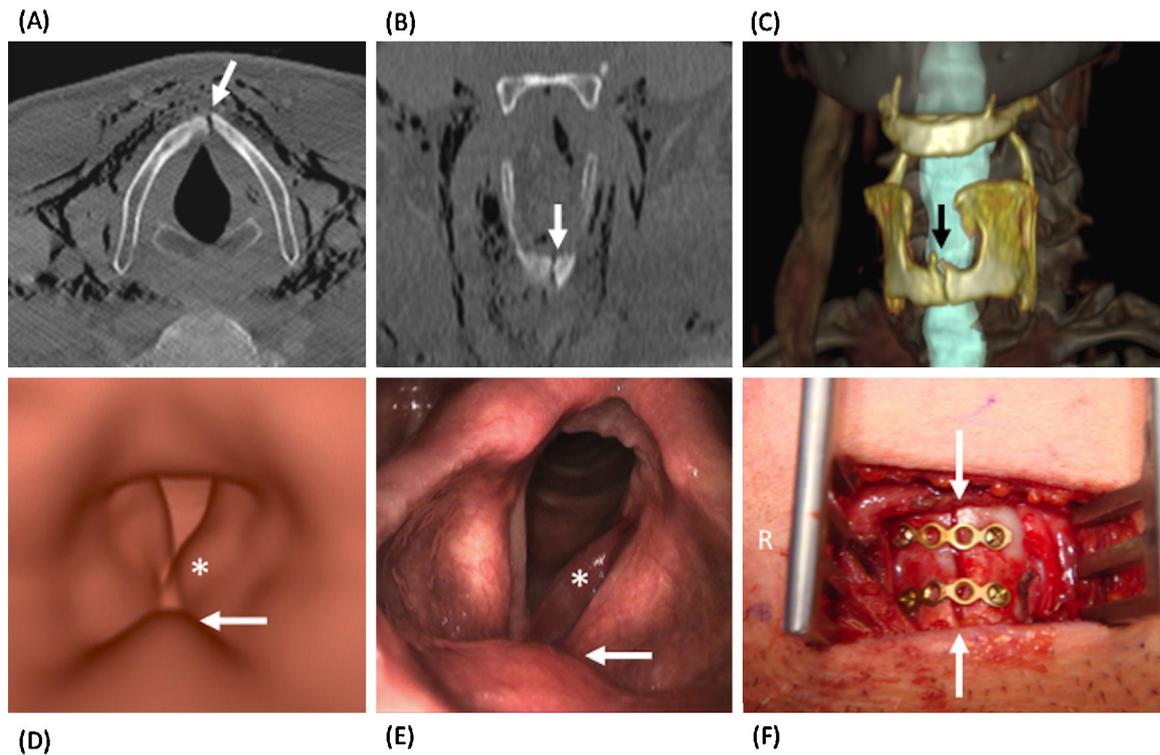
Isolated longitudinal fracture of the thyroid cartilage due to motor vehicle accident. Axial (A) and coronal (B) 2D MPR with bone windows show a paramedian, longitudinal fracture of the thyroid cartilage (arrows) with major soft tissue emphysema. (C) 3D VR (anterior view) of the thyroid cartilage (yellow) and airways (blue) depicts the cranio-caudal extent of the fracture line (arrow) more precisely. Note that in this young patient, the thyroid cartilage is poorly ossified in its anterior portion. (D) VE image shows slight bulging of the left anterior vocal cord (asterisk) due to localized hematoma and inward bulging of the anterior commissure (arrow) due to the underlying fracture line. (E) Corresponding endoscopic image confirms the VE findings. Hematoma of the anterior left vocal cord (asterisk) and anterior submucosal bulging due to thyroid cartilage fracture (arrow). (F) Intraoperative frontal view. R = right side. Surgery confirmed the CT findings. Arrows point at the longitudinal fracture line still visible after cartilage fixation with mini-plates.
